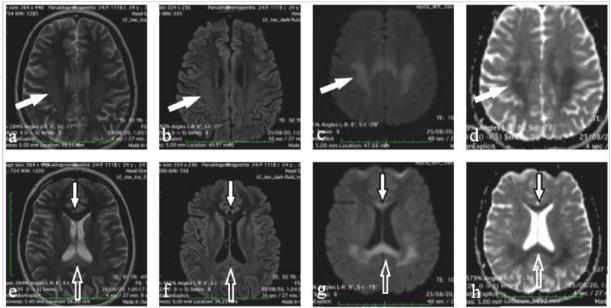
MRI axial sections of a patient showing axial T2W image (a, e), FLAIR (b, f), DWI (c, g) and corresponding ADC mapping (d, h) reveals T2 /FLAIR hyperintensity in bilateral para-sagittal parietal regions (solid arrows) and corpus callosum - genu (small arrows) and splenium (open arrows) which showed diffusion restriction appearing hyperintense on diffusion images and hypointense on ADC.
